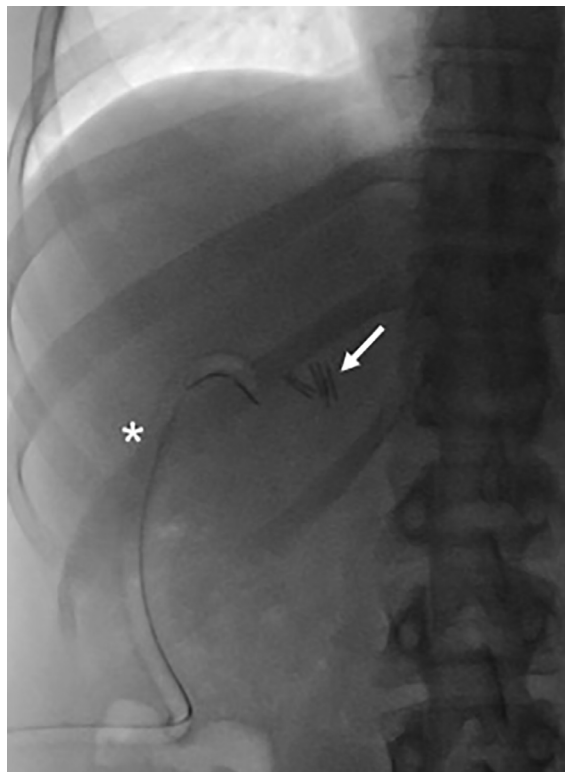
The abdomen x-ray before treatment showed the presence of a surgical drainage (asterisk) tube and surgical clips in right hypochondrium. Two clips (arrow) caused iatrogenic and pathological occlusion of the common bile duct.
